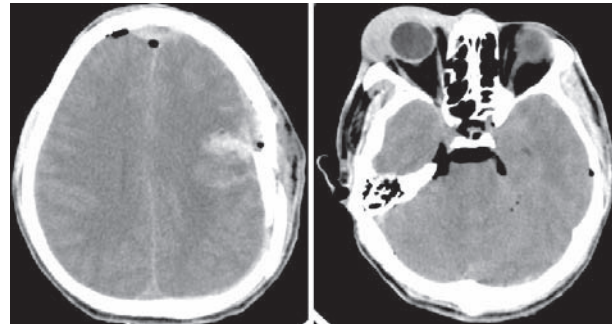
Axial cranial CT scans (soft-tissue setting) revealing severe head injury accompanied by traumatic internal pneumocephalus with air distributed prepontine, perimesencephally.
